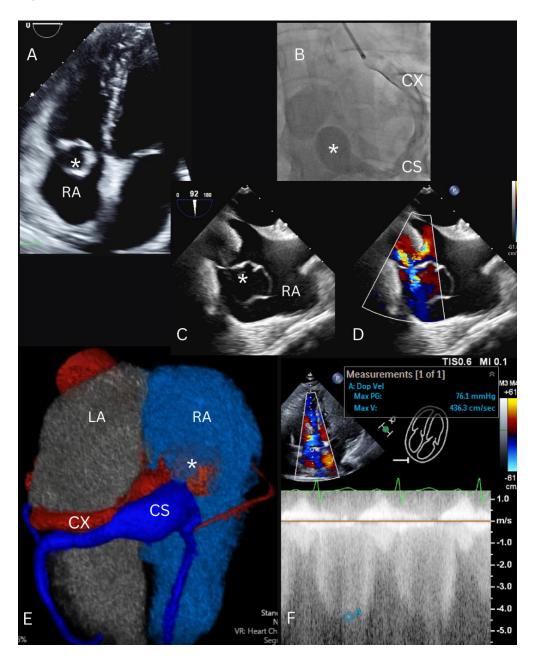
Large circumflex artery fistula to coronary sinus terminating in an exophytic varix. A: Transthoracic echocardiogram showing exophytic varix at the right atrium in close proximity to the tricuspid valve; B: Coronary angiography demonstrating the large circumflex to coronary sinus fistula, exophytic varix, and flow from the exophytic varix to the right atrium; C and D: Transesophageal echocardiography with color Doppler demonstrating flow into the right atrium and the large exophytic varix; E: Rendering reconstruction of cardiac computed tomography with emergency of the aneurysmatic left circumflex connected to coronary sinus which terminates in an exophytic varix variant in the right atrium; F: Doppler interrogation of peak flow from coronary sinus varix to right atrium in transthoracic echocardiogram, maximum gradient 76mmHg. \*: exophytic varix, CS: coronary sinus, CX: circumflex artery, LA: left atrium, RA: right atrium.
